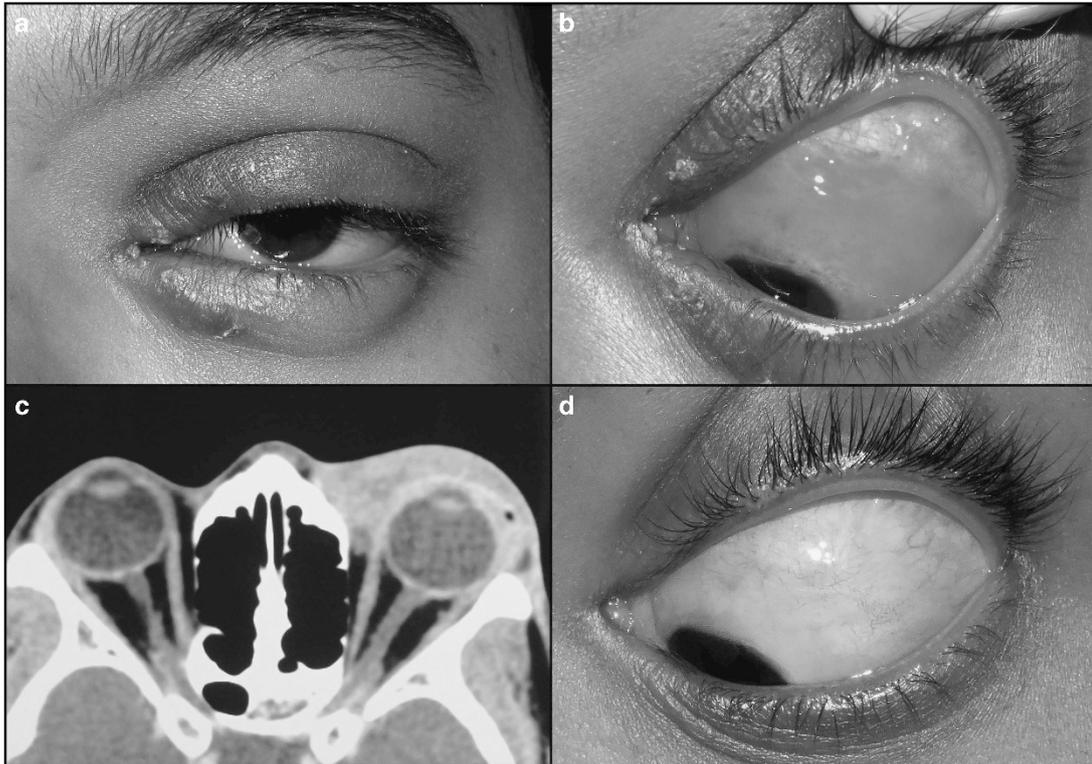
Case 3 at presentation shows eyelid swelling and ecchymosis most marked medially (a) with extensive conjunctival involvement (b). CT scan shows extent of lesion (c). At last follow-up, moderately good response to treatment is evident with regression of the conjunctival component as well as a noticeable decrease of the medial lid swelling (d).
